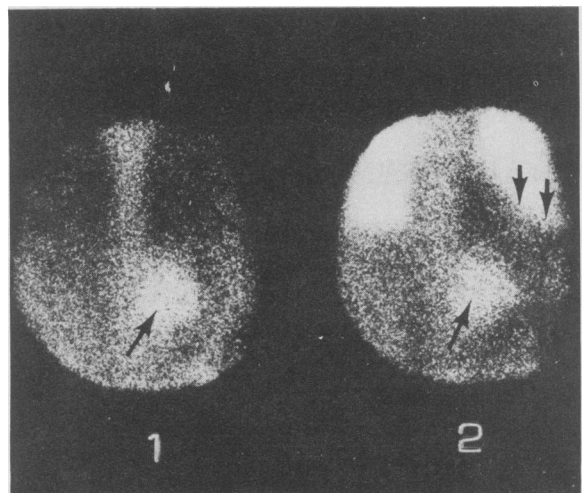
(Case 1) Anterior chest. Left, ^{67}Ga citrate scintigraph (1) shows ^{67}Ga localization at the base of the left lung. Right, a combined ^{67}Ga citrate- ^{99m}Tc -human albumin microsphere study (2) shows the ^{67}Ga localization to be below rather than within the left lower lobe (see Figure 1).
